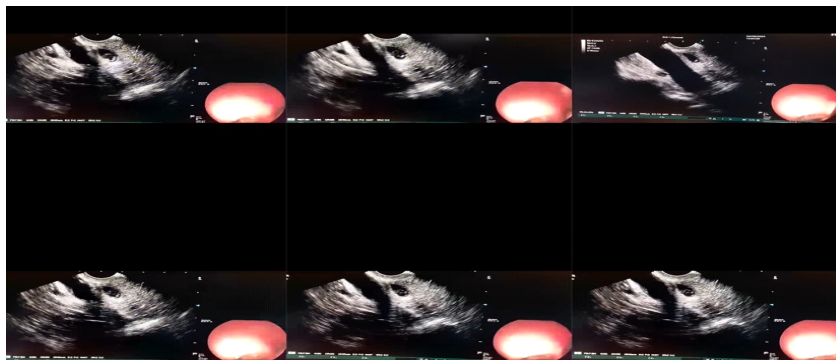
Image of the parasite on endoscopic ultrasonography
